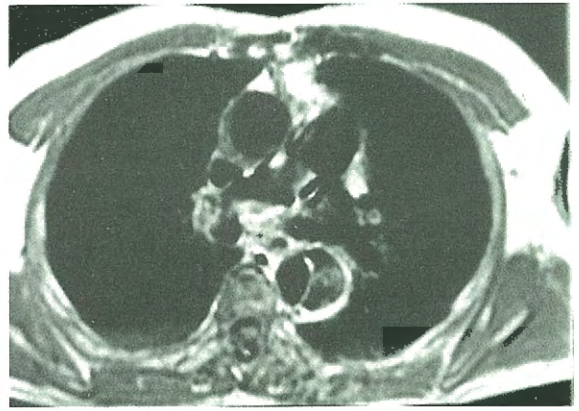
Magnetic resonance image obtained 6 months after the operation. No flow signal was detected in the false lumen.
